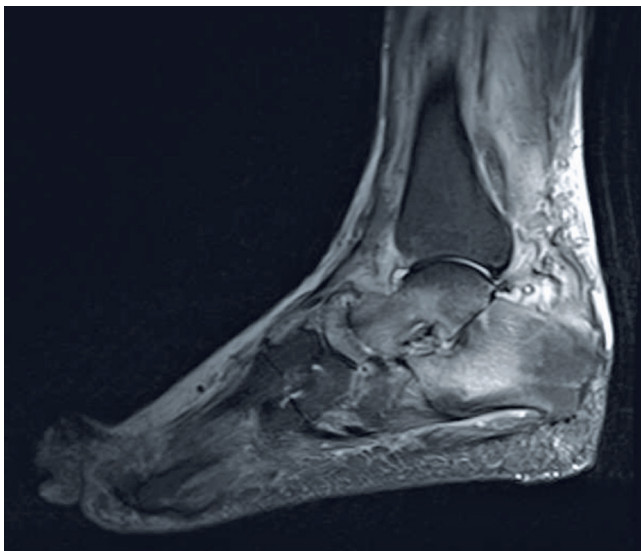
Mid-sagittal view magnetic resonance imaging scan. Navicular bone showing increased signal intensity, more evident post-gadolinium, with erosion of its posterior margin, suggesting osteolysis. Talus bone exhibiting increased signal intensity, more prominent post-gadolinium, with erosion of its anterior and inferior margins, suggesting osteolysis. Calcaneus bone displaying increased signal intensity, more evident post-gadolinium, with erosion of its superior margin at the sinus tarsi, suggesting osteolysis.
